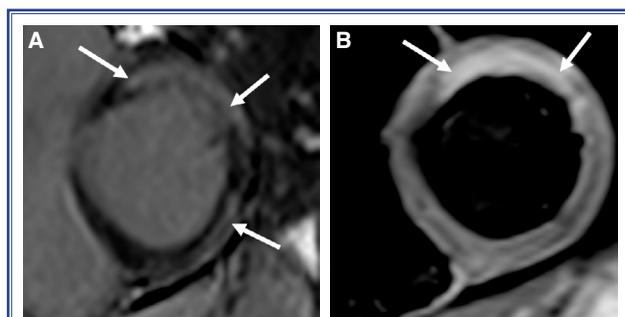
An 18-year-old male patient with acute myocarditis. (A) Late gadolinium enhancement (LGE) image shows an increased signal in the anterior and anterolateral wall extending from the midmyocardial to the subendocardial area, as well as the subepicardial area in the inferolateral wall (arrows). (B) TRIM T2-weighted image of the same patient shows midmyocardial to subendocardial signal increase in the anterior wall (arrows).
